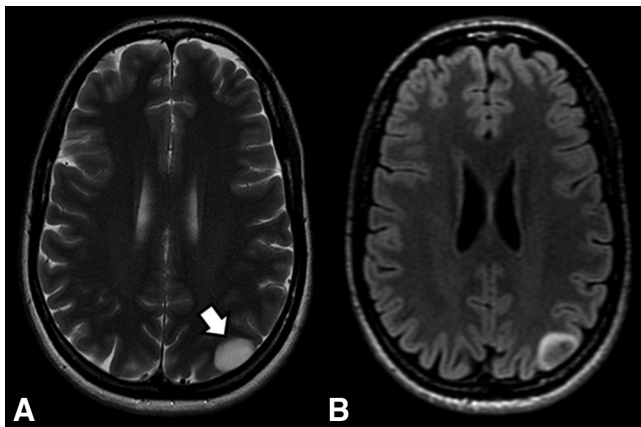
DNET. Axial T2WI (A) and FLAIR imaging (B) show an extratemporal DNET presenting with the so-called mismatch sign. The lesion is hyperintense on T2WI (arrow in A) with central hypointensity on FLAIR imaging (B).
